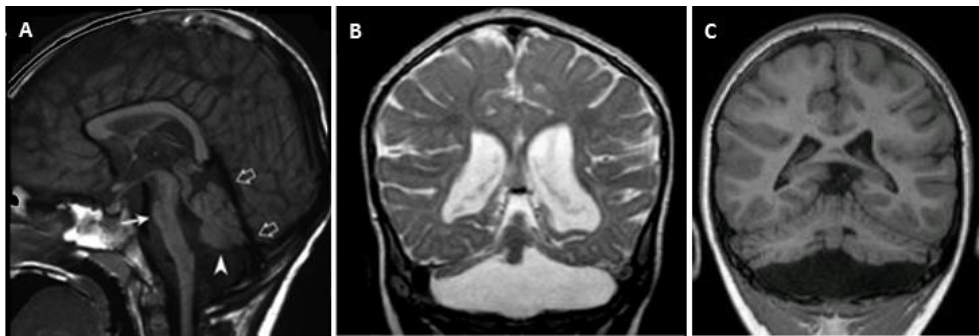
Midsagittal MR image showing hypoplasia of the pons and cerebellum (A); coronal images showing a cerebellar hypoplasia with more severe involvement of the cerebellar hemispheres with respect to the vermis (dragonfly appearance) (B) and a less severe hypoplasia of the cerebellar hemispheres (butterfly appearance) (C).
